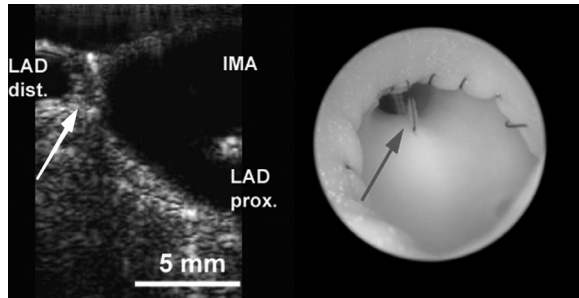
Suture cross-over anastomosis: panels from left to right, transverse and longitudinal ultrasound image, angiogram and angioscopic image taken from the IMA towards the outflow corner. Note in the longitudinal ultrasound image the suture traversing twice the anastomotic orifice (arrow). The transverse image was taken at the level of the overcrossing suture. The anastomosis appeared normal on the angiogram. IMA, internal mammary artery; LAD, left anterior descending coronary artery; Prox, proximal; Dist, distal.
